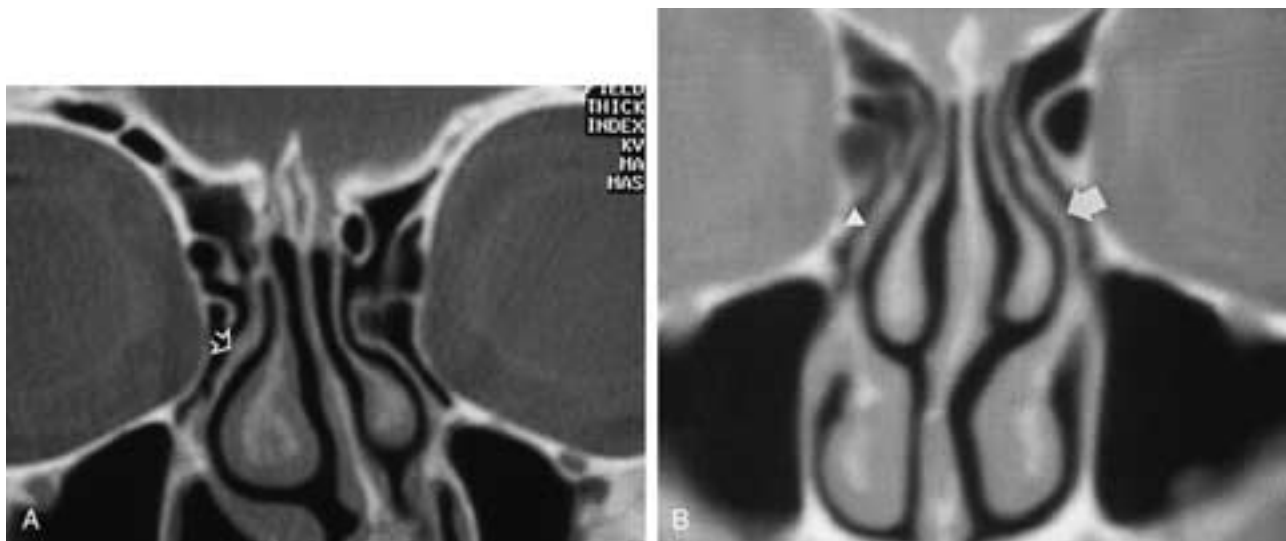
Variations in the superior attachment of the uncinate process. A, Coronal CT image obtained at the level of the frontal recess reveals that the right uncinate process (*open arrow*) attaches to the superior right middle turbinate. B, Coronal CT image reveals that the left uncinate process (*solid arrow*) attaches to the roof of the ethmoid sinus. On the right side, the uncinate (*arrowhead*) adheres to the medial agger nasi cell and frontal cell.
